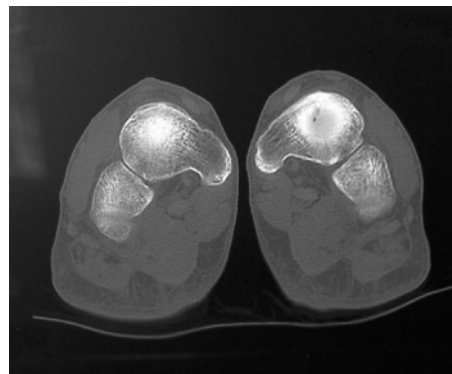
Navicular computed tomography. Scan from a patient who reported maximum function and no current pain on questionnaire. Despite having returned to full competition for years, and later retiring, a radiolucent cleft remains visible in the body of the left navicular.
